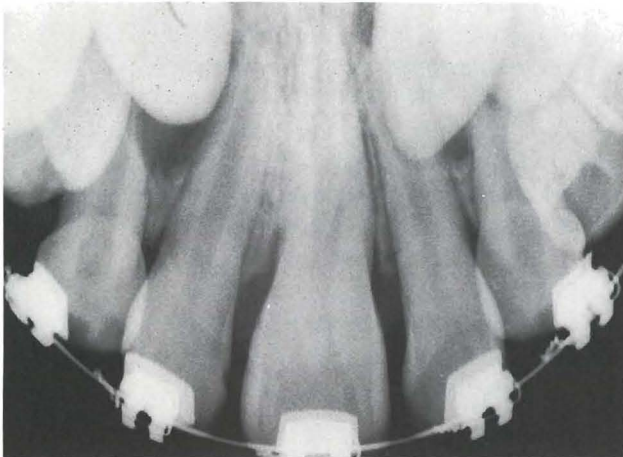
Case 2 periapical radiograph. Normal shape of a single-rooted right incisor.
